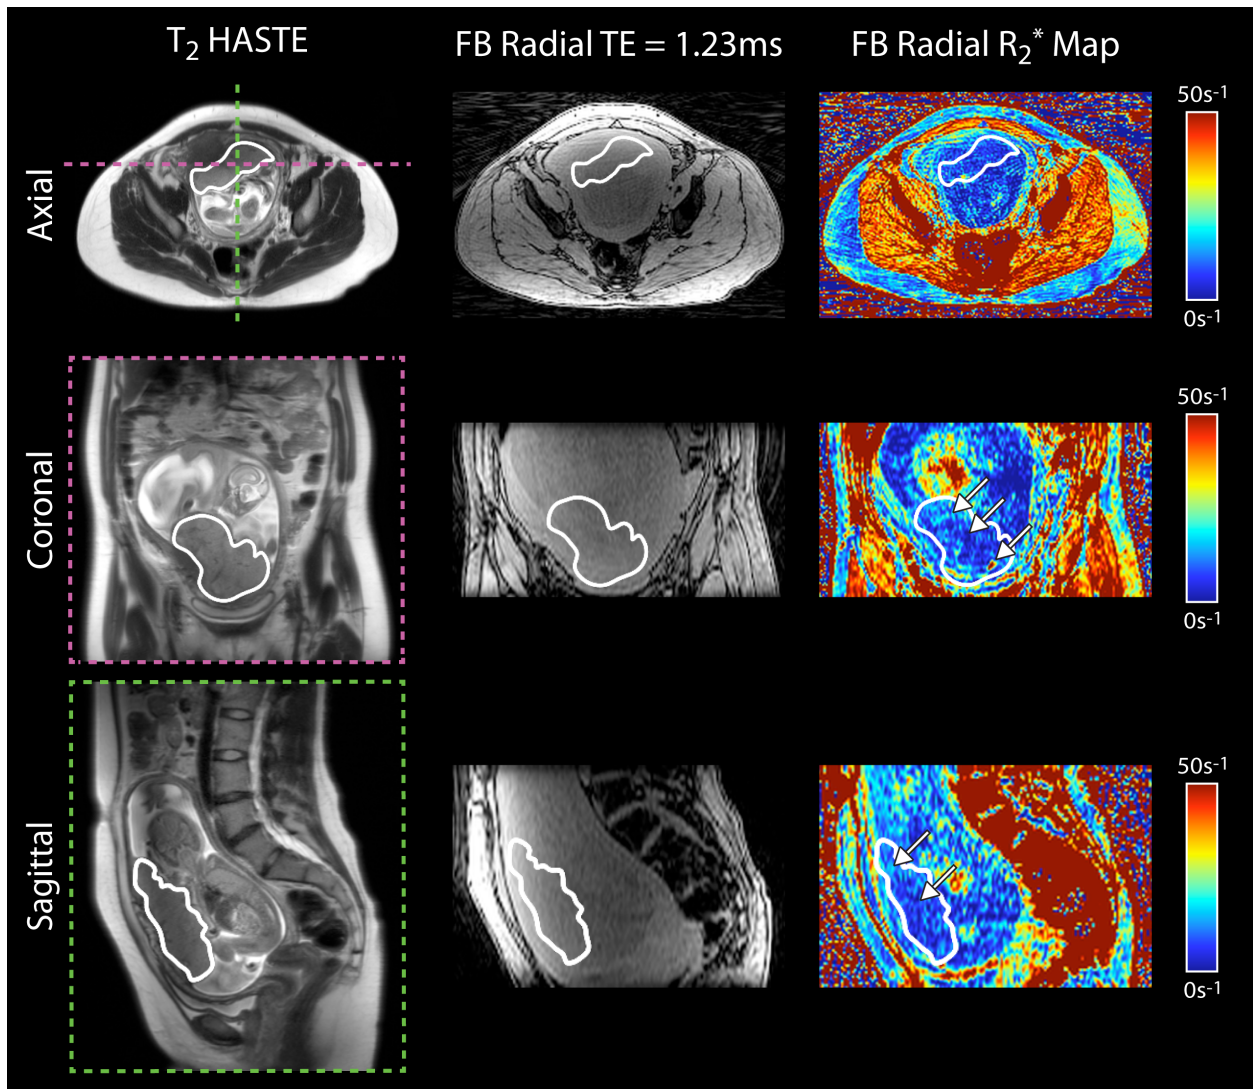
Representative in vivo placenta images and R_2^* maps of a subject with preeclampsia at 19+1 weeks gestational age acquired using free-breathing radial MRI at 3 T. Axial, coronal and sagittal views are shown. The placenta is delineated by a white contour. White arrows on the R_2^* maps point to spatial variation. In this subject, there were regions of higher R_2^* along the periphery and regions of lower R_2^* in the center of the placenta.
